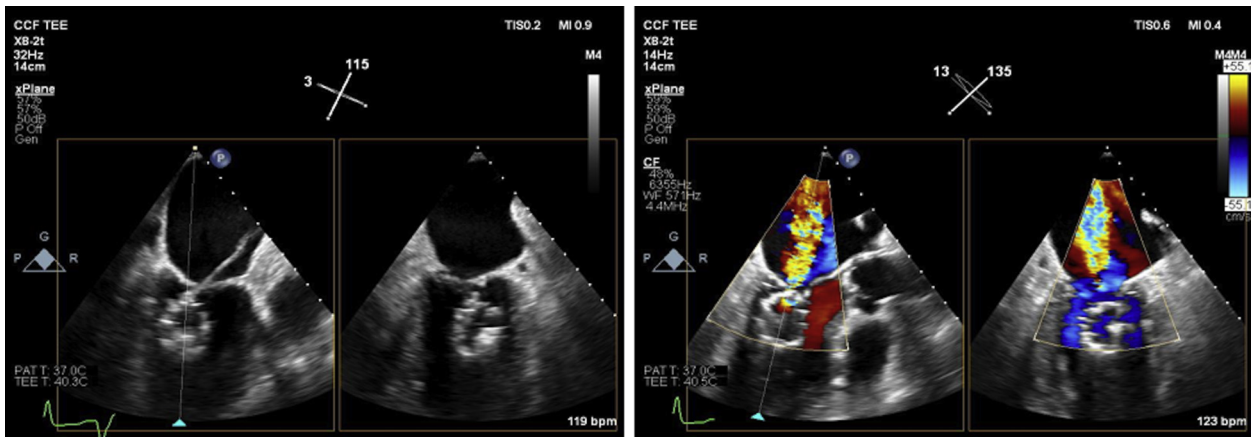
Transesophageal Echocardiography Showing the Attempt to Retrieve the Device Transseptally Resulting in Severe Mitral Regurgitation
